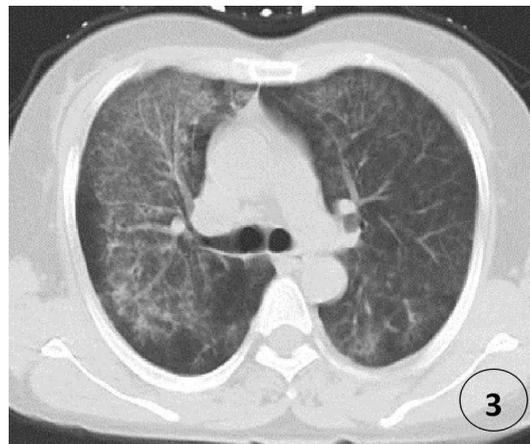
Axial unenhanced chest CT after one and two weeks' treatment with hormone and immunosuppressive show the lesions are obviously absorbed, and vanish.
